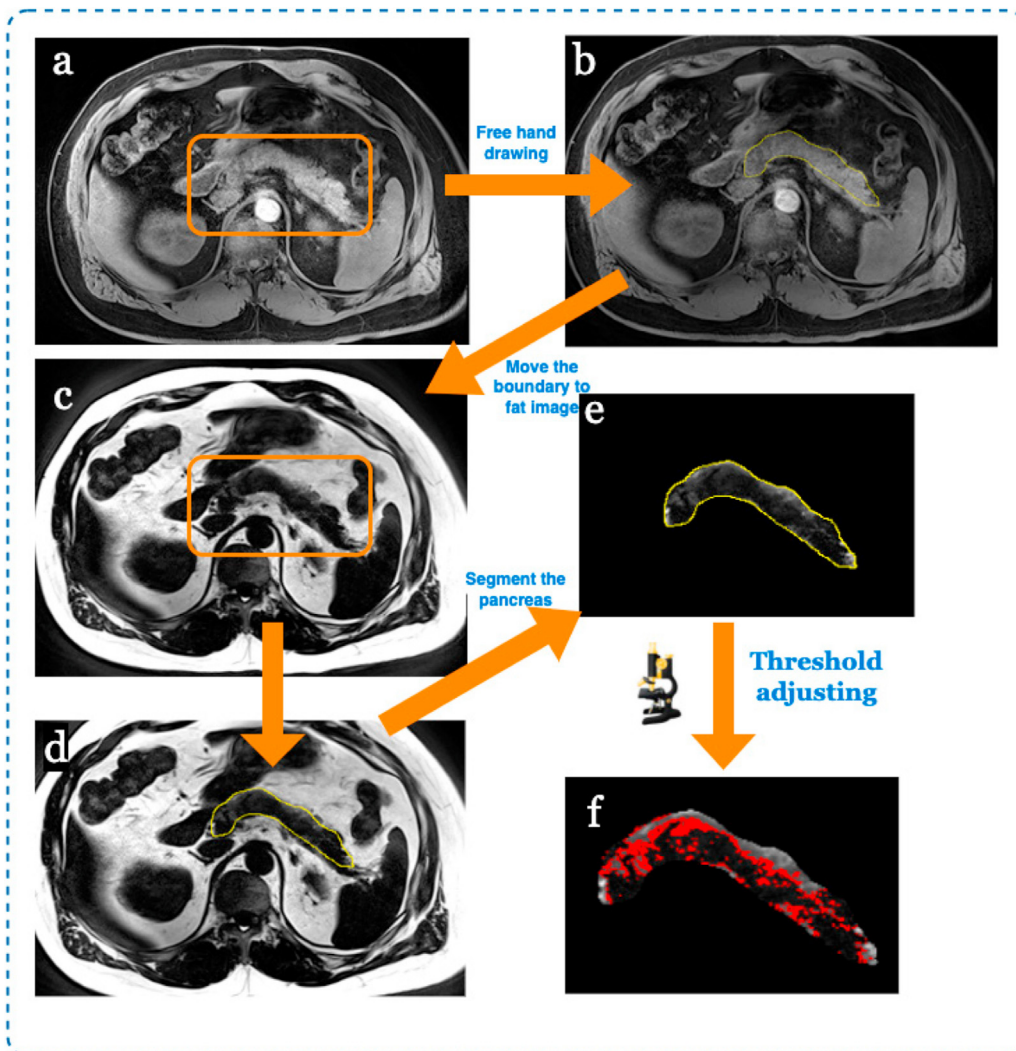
The manual MRI segmentation process for pancreatic fat fraction. a.) the water image with centered pancreas. b.) the corresponding fat image with centered pancreas. c.) manual segmentation of the pancreas. d.) transfer of the pancreas boundary from water image to fat image. e.) pancreas segmented from the fat image. f.) threshold adjusted until most of the inner pancreas pixels were covered. Using Image J to measure the percentage fat for all highlighted RoiSets within the ROI manager. The final fat percentage was obtained by excluding values less than 1% and over 20% on excel spreadsheet generated by Histogram on Image J.
